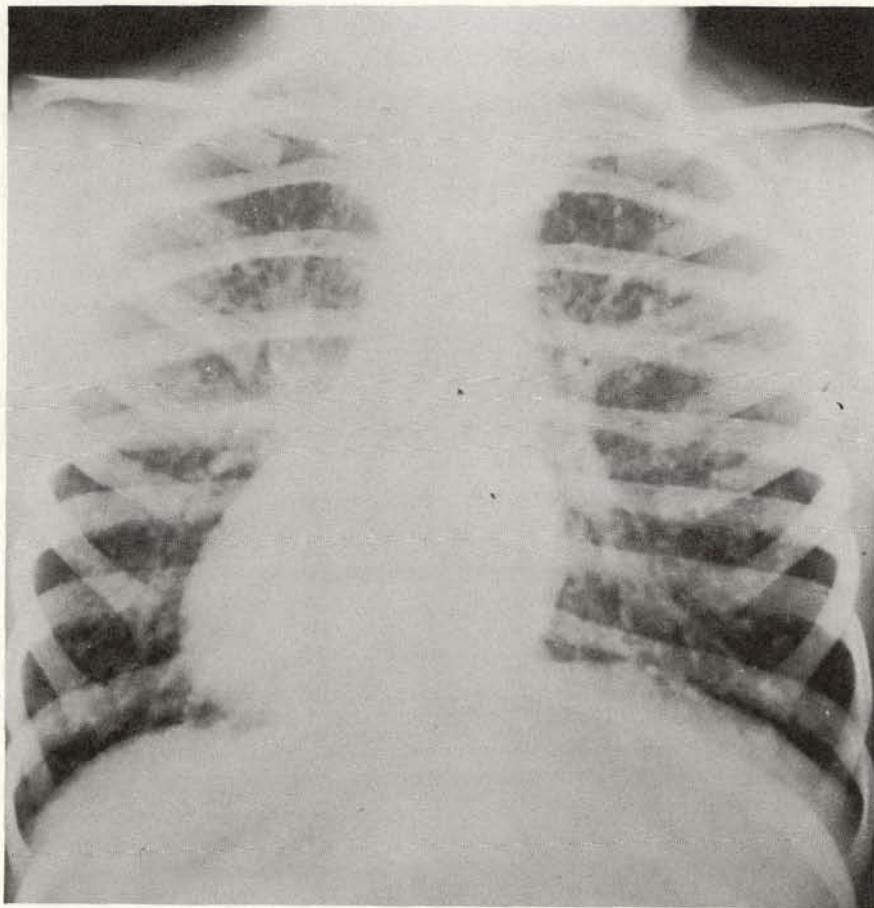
Roentgenograph of chest of 4-yr.-old girl showing diffuse miliary type spread of carcinoma of the thyroid.
